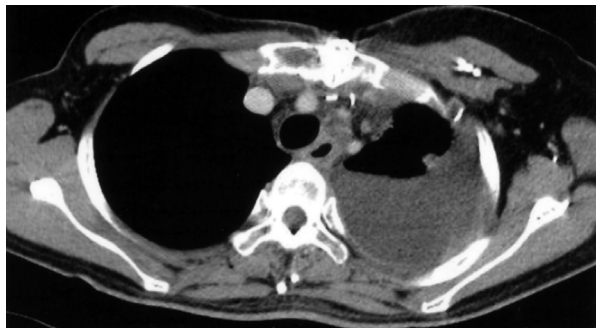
Suspicious soft tissue density with involvement of the anterior chest wall was noted on the chest CT scan.
